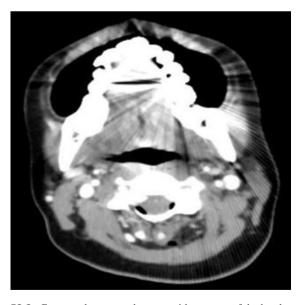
Computed tomography scan with contrast of the head, neck, and soft tissue revealing cervical 1 through cervical 4 epidural air exiting into the right paraspinal and posterior subcutaneous tissue of the neck, tracking along fascial planes
